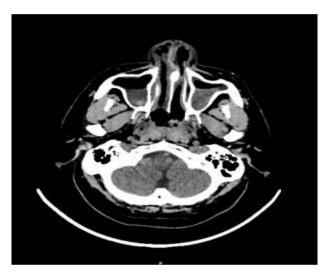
CT PNS with contrast shows hemo sinus without any active extravasation of contrast.
